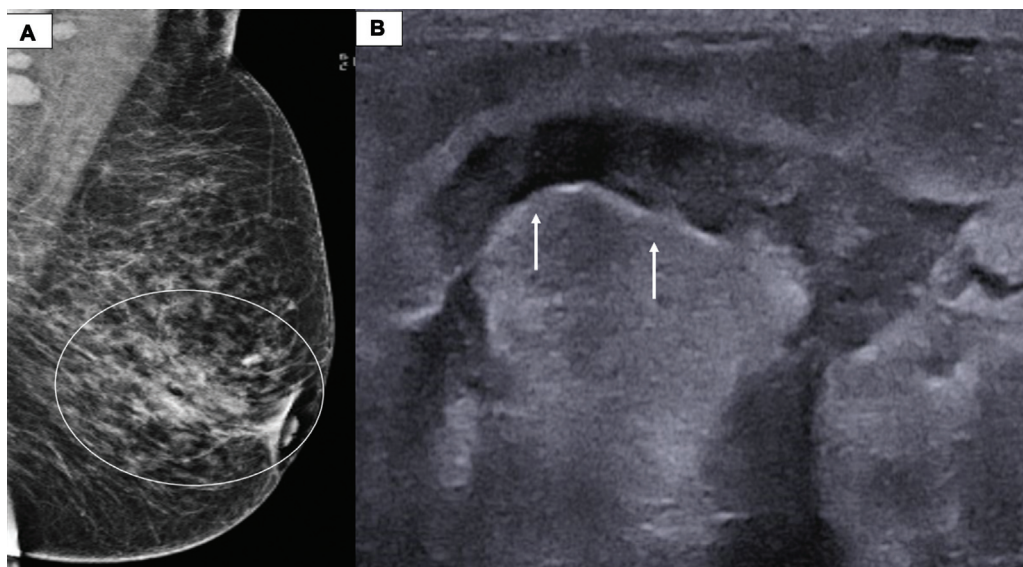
Granulomatous mastitis with nonmass imaging features. (A) Single mediolateral oblique mammogram of left breast shows architectural distortion extending to retroareolar location with nipple retraction (encircled). (B) corroborative ultrasound (US) revealed fluid tracking channels with internal echoes (arrows). No definite mass noted. US-guided biopsy diagnosed it as granulomatous mastitis.
